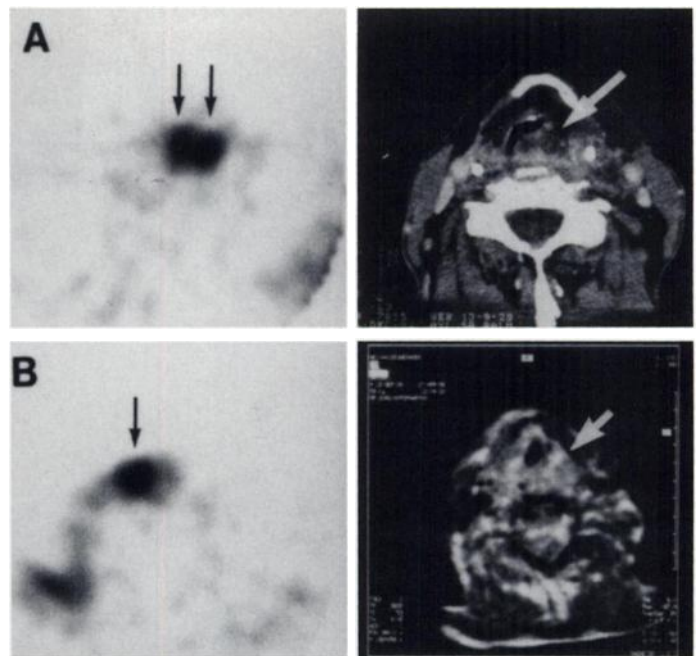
(A) Transaxial images of ^{201}Tl SPECT (left) and enhanced CT (right) of a patient with a larynx carcinoma showing an intense uptake (black arrows) at the tumor site in left area of larynx with extension to the right side (white arrow). (B) After radiotherapy, persistent uptake is seen in right part of tumor (black arrow), whereas on MRI (only T1-weighted spin-echo image after intravenous contrast medium is shown) tumor cannot be differentiated from reactive tissue changes (white arrow).
